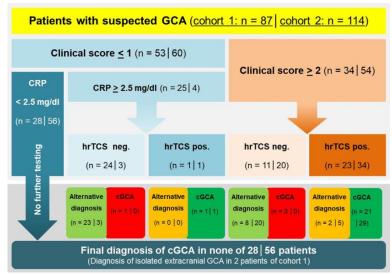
Setup of the diagnostic algorithm integrating the clinical score, a CRP cut-off of  $\geq$  2.5 mg/dl in patients with low clinical probability, and hrTCS in patients with low clinical probability exhibiting CRP-values above the cut-off of  $\geq$  2.5 mg/dl, as well as in all patients with non-low clinical probability regardless of CRP-values. Patients with low clinical probability and a CRP-value < 2.5 mg/dl are not assigned to undergo sonographic imaging.
